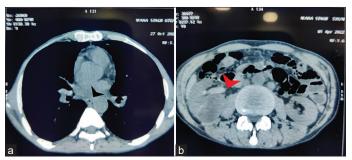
(a) CT scan thorax showing complete obstruction of esophageal lumen due to soft-tissue mass; (b) CT scan abdomen showing a right renal mass (Case 3)
